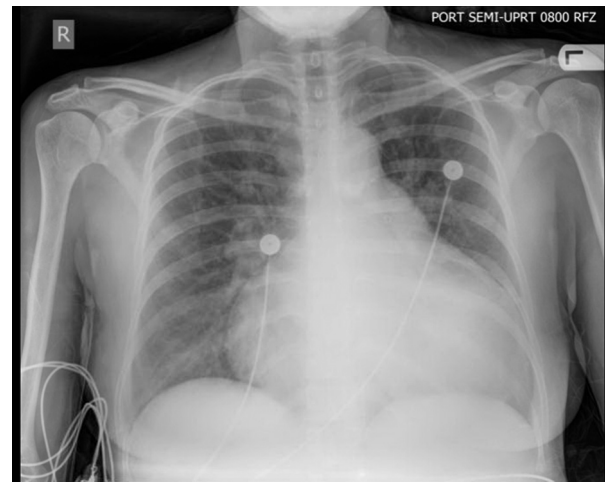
Chest X-ray showing prominent cardiomegaly, pulmonary vascular congestion, and central prominence of the main pulmonary artery segment suggestive of pulmonary artery hypertension.
